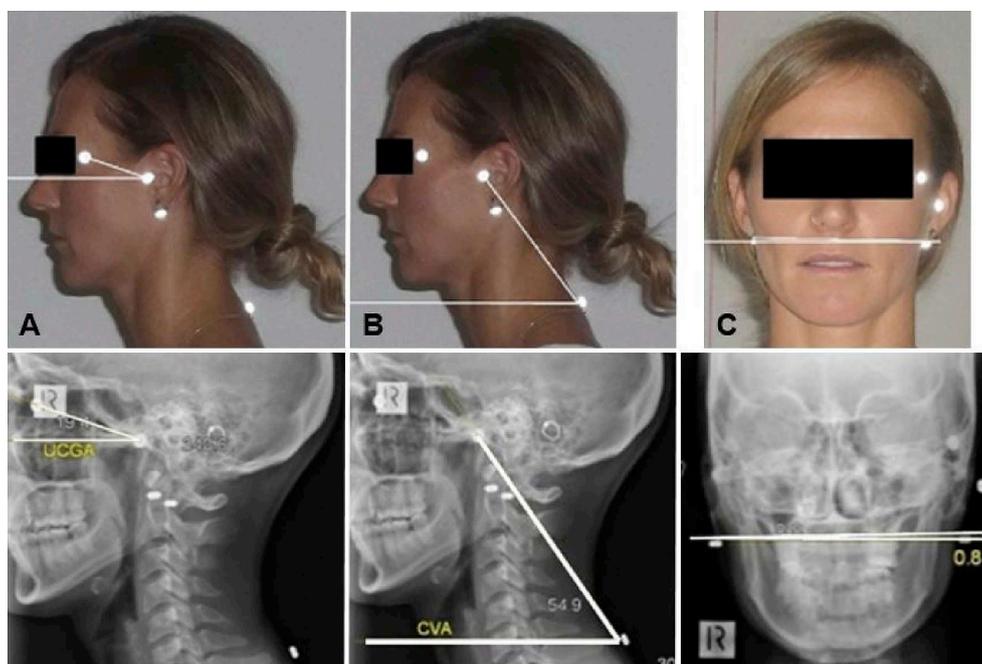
Anatomical landmarks, photogrammetric and radiographic image digitization. Ledger: Sagittal Plane: A. Upper Cervical Gaze Angle (UCGA), B. Craniovertebral Angle (CVA). Coronal Plane: C. Lateral Head Tilt Angle (LHTA).
